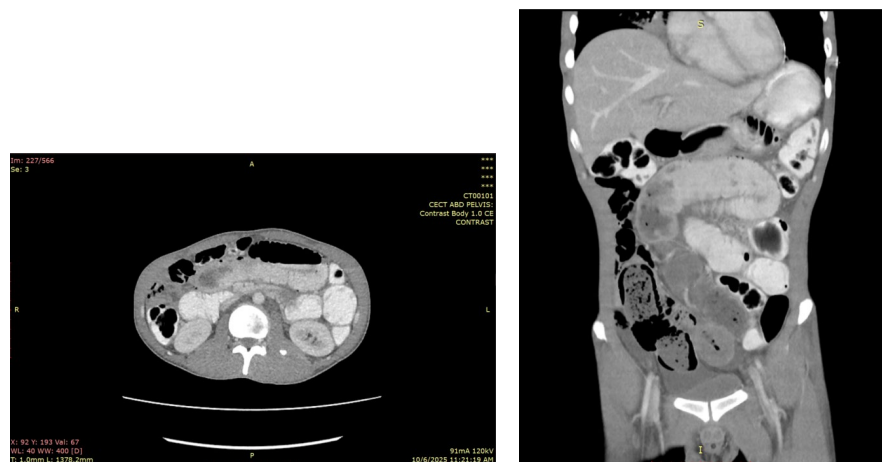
Axial and coronal contrast-enhanced CT of the abdomen and pelvis showing a heterogeneously enhancing intraluminal soft tissue mass in the small bowel with proximal bowel dilatation, consistent with small bowel obstruction.
